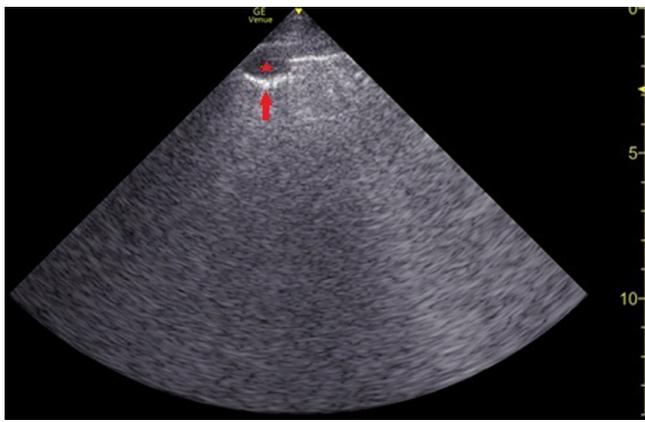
Left lung ultrasound with sub-pleural consolidation (star) and C-profile (arrow) indicating a pneumonia.
